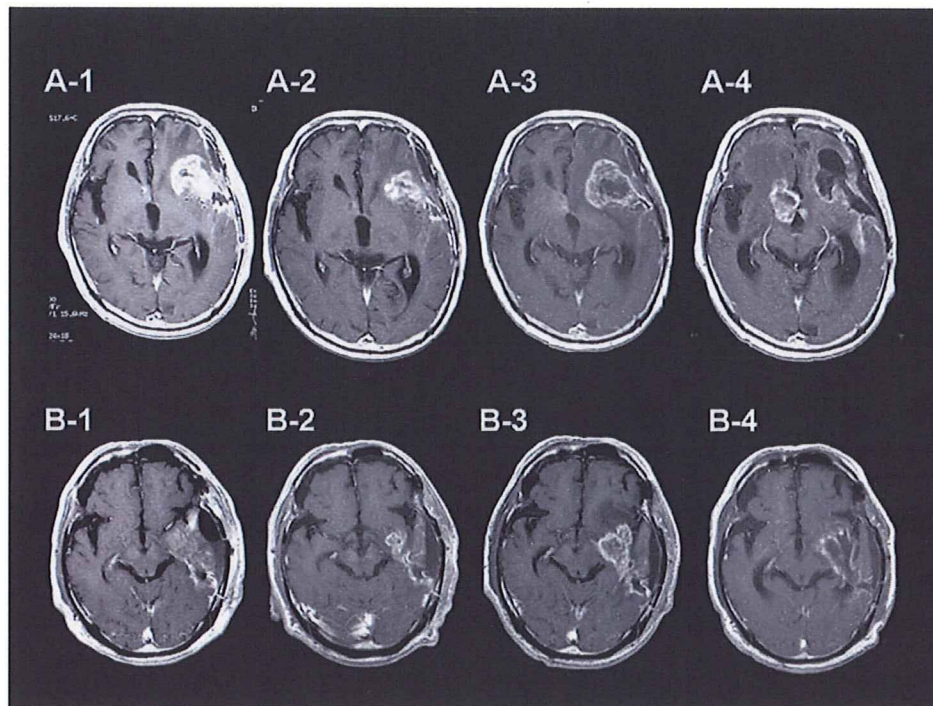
Two representative cases of pseudoprogression of newly diagnosed glioblastoma multiforme treated by boron neutron capture therapy (BNCT). (A-1–A-4) Gadolinium (Gd)-enhanced MR images of case 5: prior to BNCT (A-1), 5 weeks after BNCT (A-2), 2 months after BNCT (A-3), and 6 months after BNCT and 3 months after second craniotomy (A-4). Case 5 was operated on 3 months after BNCT for the suspicion of tumor progression (judged from A-3). The operated lesion was stable for more than 3 months without chemotherapy. (B-1–B-4) Gd-enhanced MR images of case 35: prior to BNCT (B-1), 1 month after BNCT (B-2), 2 months after BNCT (B-3), and 7 months after BNCT (B-4).
